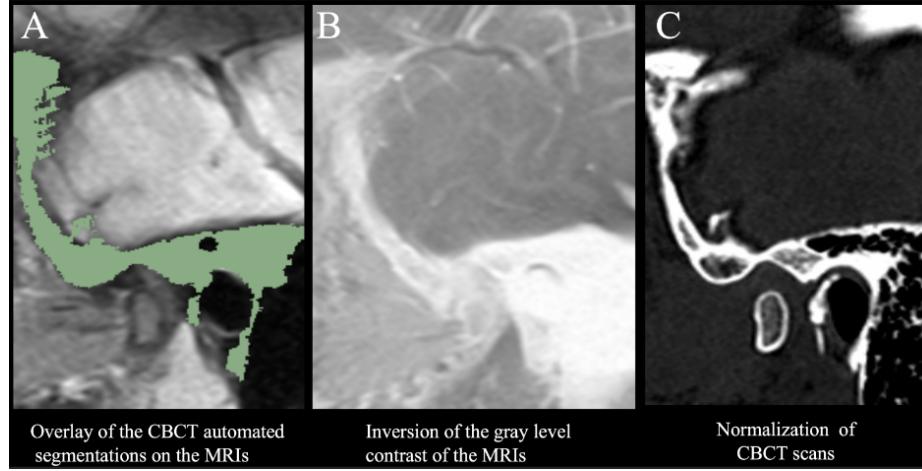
Preprocessing steps for MRI-CBCT registration. (A) Overlay of the automated CBCT segmentation (shown in green) on the MRI scan, highlighting the cranial base as a stable region of reference. (B) Inversion of the gray level contrast of the MRIs to better match the intensity characteristics of the CBCT scan, facilitating the registration process. (C) Normalization of the CBCT scan to achieve consistent intensity scales over the regions of interest between the MRI and CBCT images.
